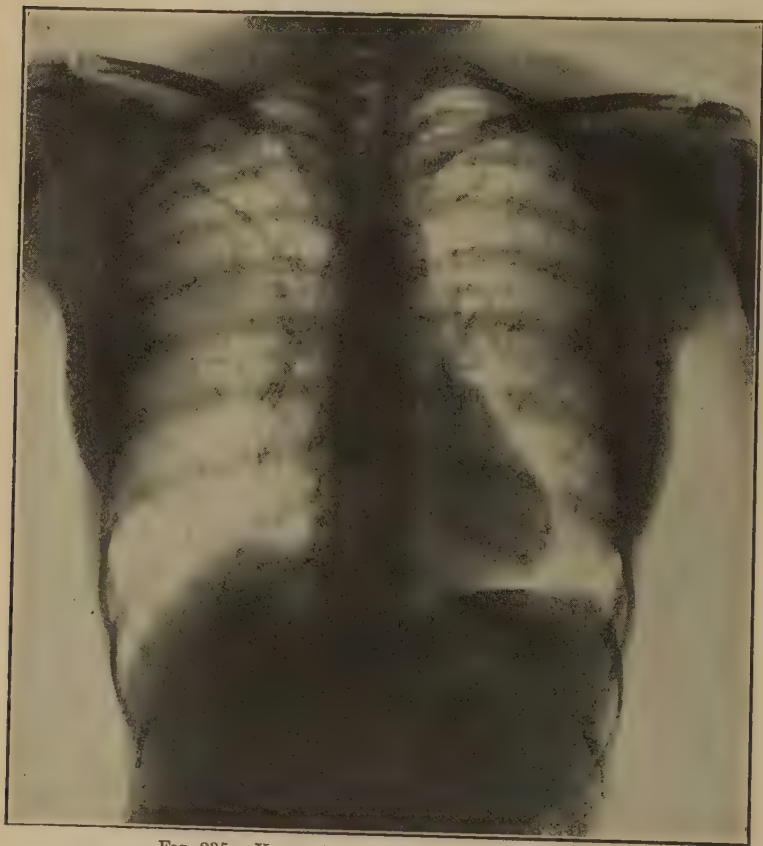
X-ray of chest, showing slender bones.
